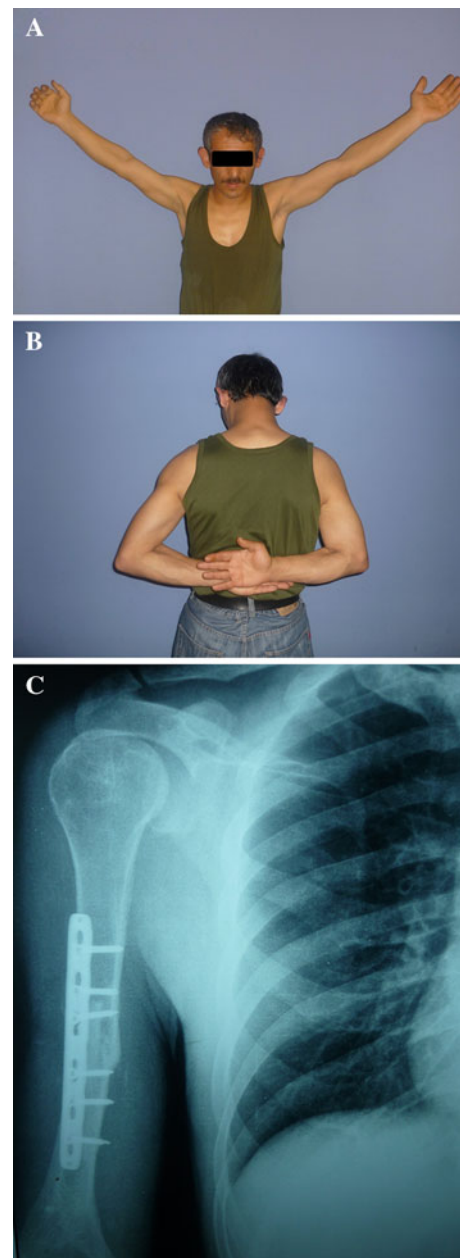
a–c Postoperative clinical situation and radiographs of the patient
